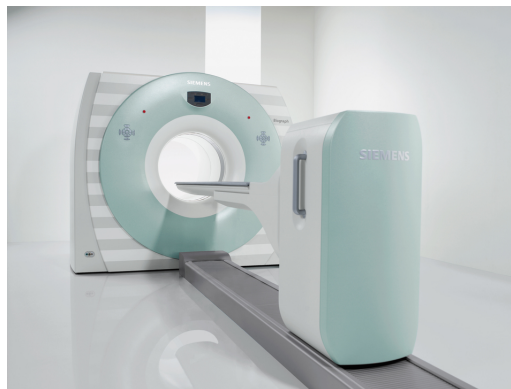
The Siemens Biograph TruePoint PET/CT scanner [32]. Patients lie on the bed inside the cylindrical scanner.*
